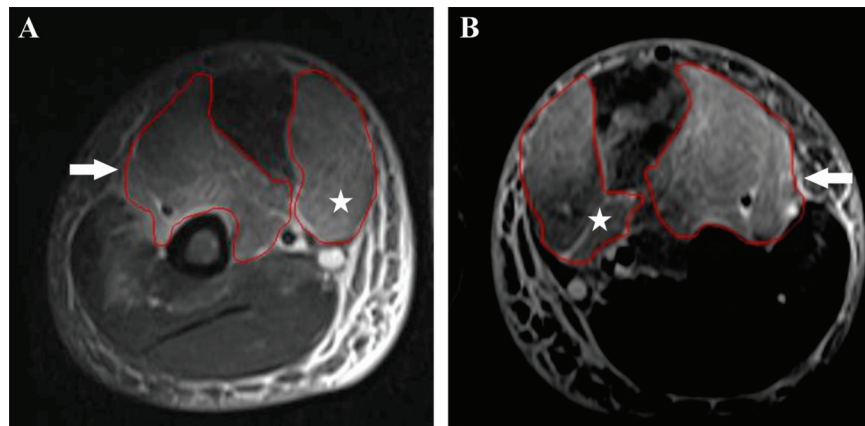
Magnetic resonance imaging of the arms, taken at 72 hours of evolution
